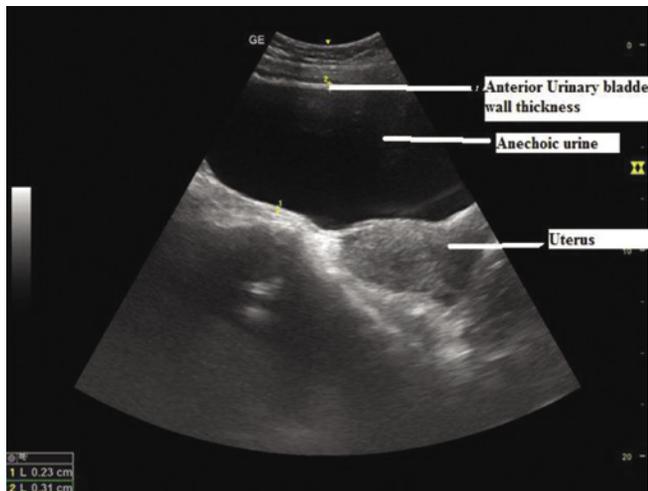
Sonographic image of the urinary bladder-longitudinal view showing the urinary bladder wall thickness in a female, with the uterus shown posterior to the urine distended urinary bladder
